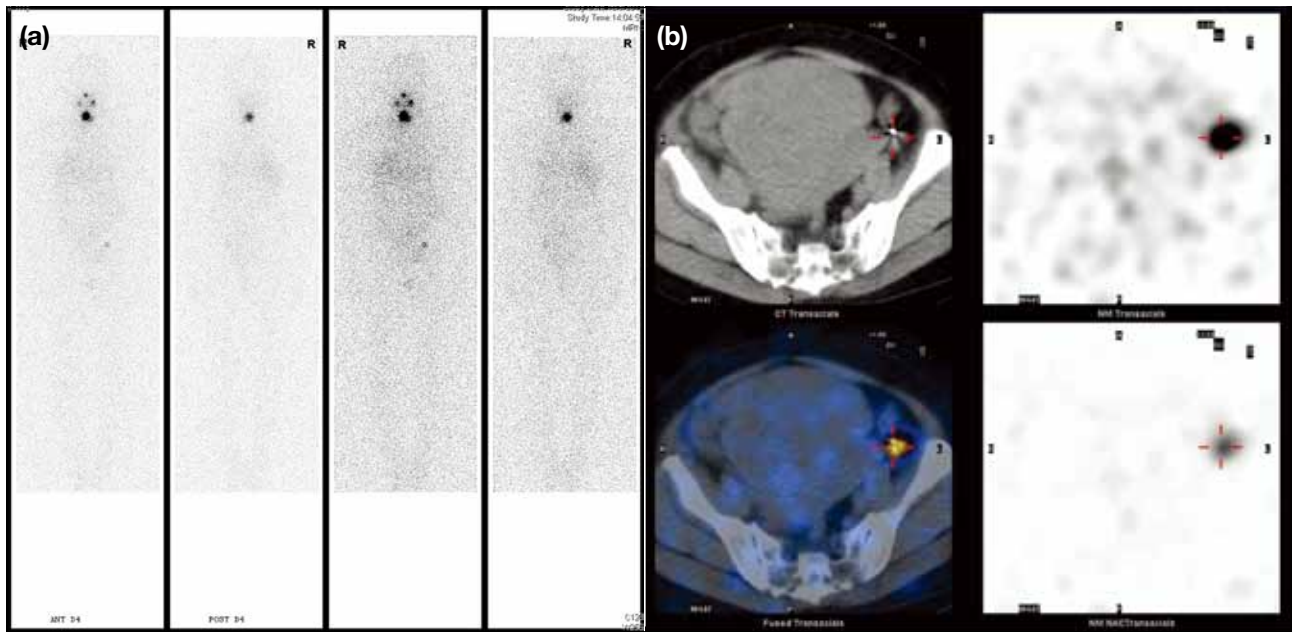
(a) Whole-body biplanar images show intense uptake in the neck suggestive of residual malignancy and equivocal intense focal uptake in the left lower quadrant. (b) Transaxial SPECT/CT fusion images show that the uptake in the left lower quadrant corresponds to an intraperitoneal metallic structure.
